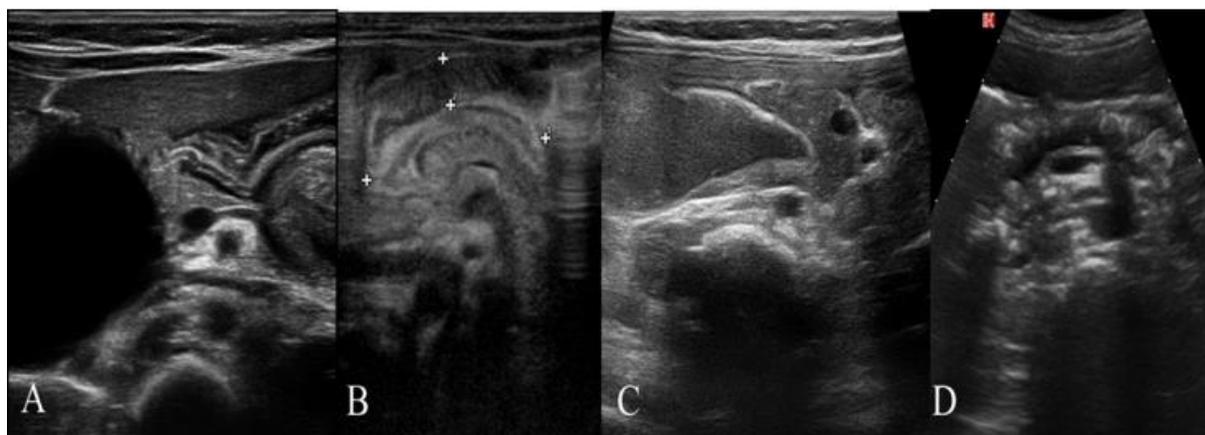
The sonographic appearance of some pathologies in epigastric area and their relations with mesenteric vessels: A) Cholangiocyst, B) Hypertrophic pyloric stenosis, C) Duodenal obstruction, and D) chronic pancreatitis.
